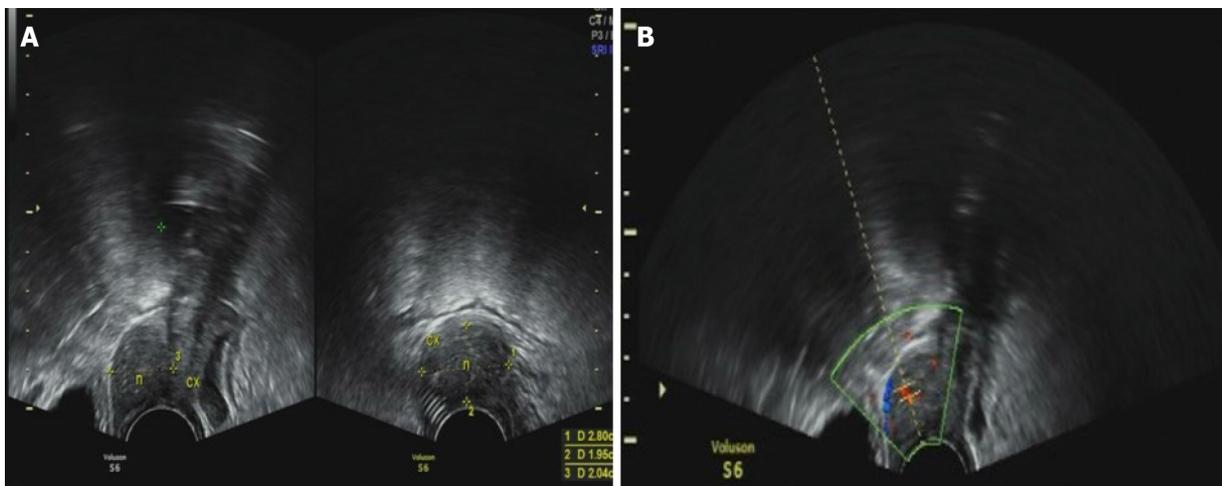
Transvaginal ultrasound images. A: The thickness of cervix was about 2.8 cm. The thickness of anterior lip was obvious; B: There was a hypoechoic solid nodule with the diameter of 3 cm, with unclear boundary and a dotted blood flow signal. RI: 0.56.cx (cervix), n (nodule).
